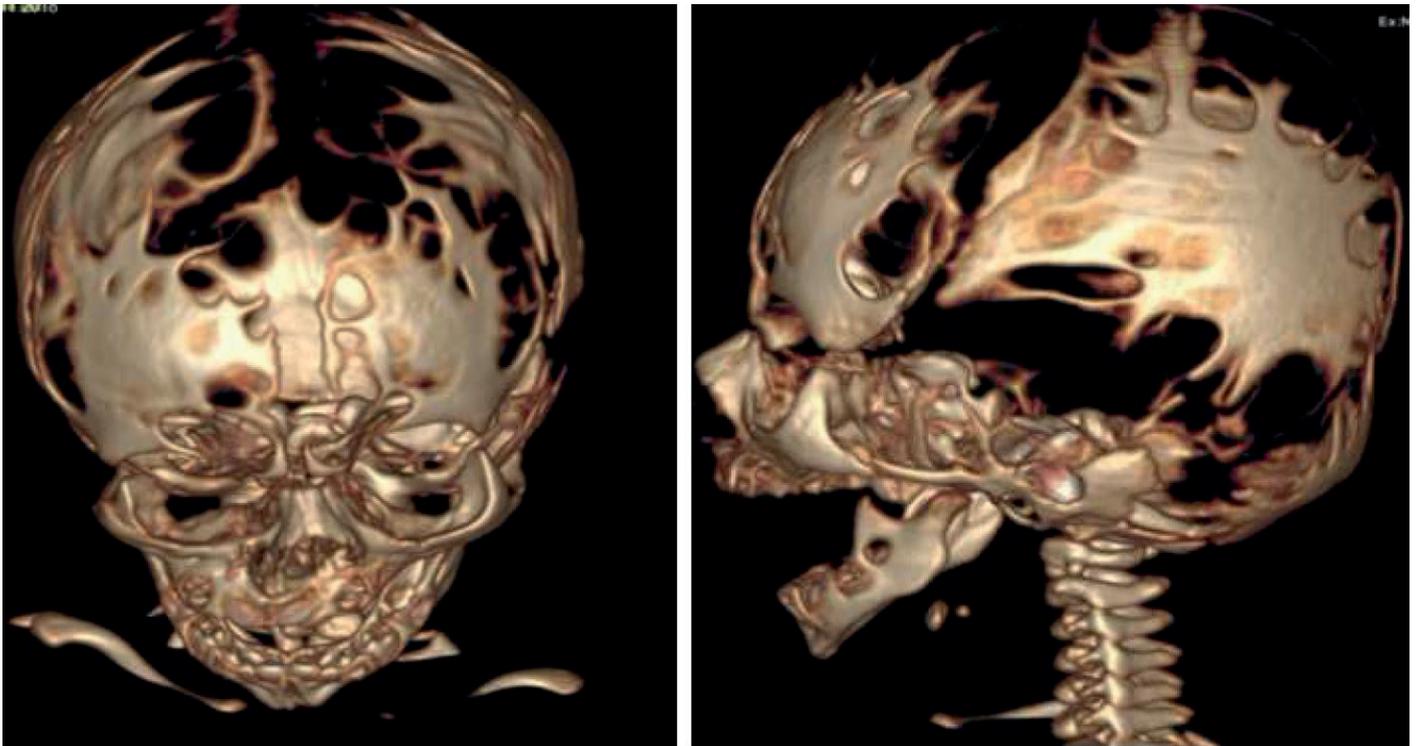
Three-dimensional computed tomography scan revealed multiple oval and round lacunae at parietal and frontal areas which were in the tendency to join
